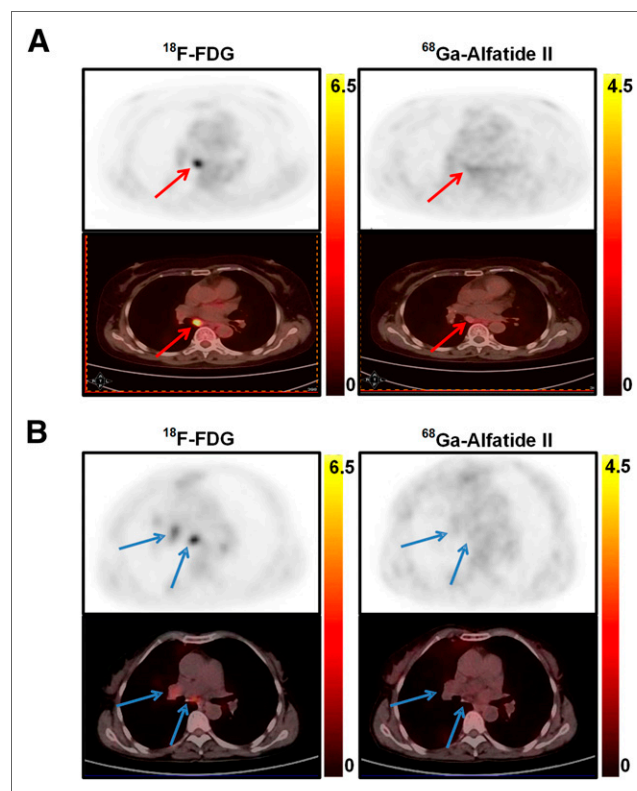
(A) Representative transaxial ^{18}F -FDG and ^{68}Ga -Alfatide II PET and PET/CT images of adenocarcinoma patient. Suggestive LNs are indicated by red arrows. ^{18}F -FDG represented positive uptake, whereas ^{68}Ga -Alfatide II represented negative uptake. Postoperative pathology of this LN is benign, and final clinical staging of this patient was T2aN0M0. (B) Representative images of TB patient. Benign reactive LNs are indicated by blue arrows.
